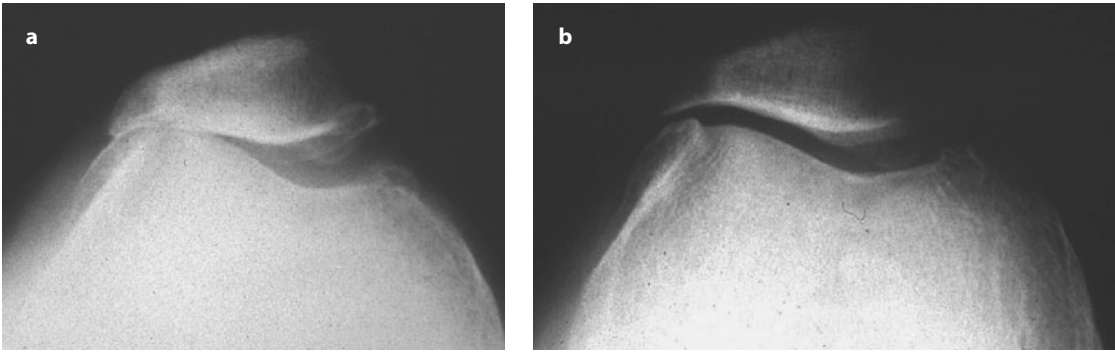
a, b Skyline X-rays taken in different degrees of flexion, demonstrating the more obvious pathology in one knee than in the other
